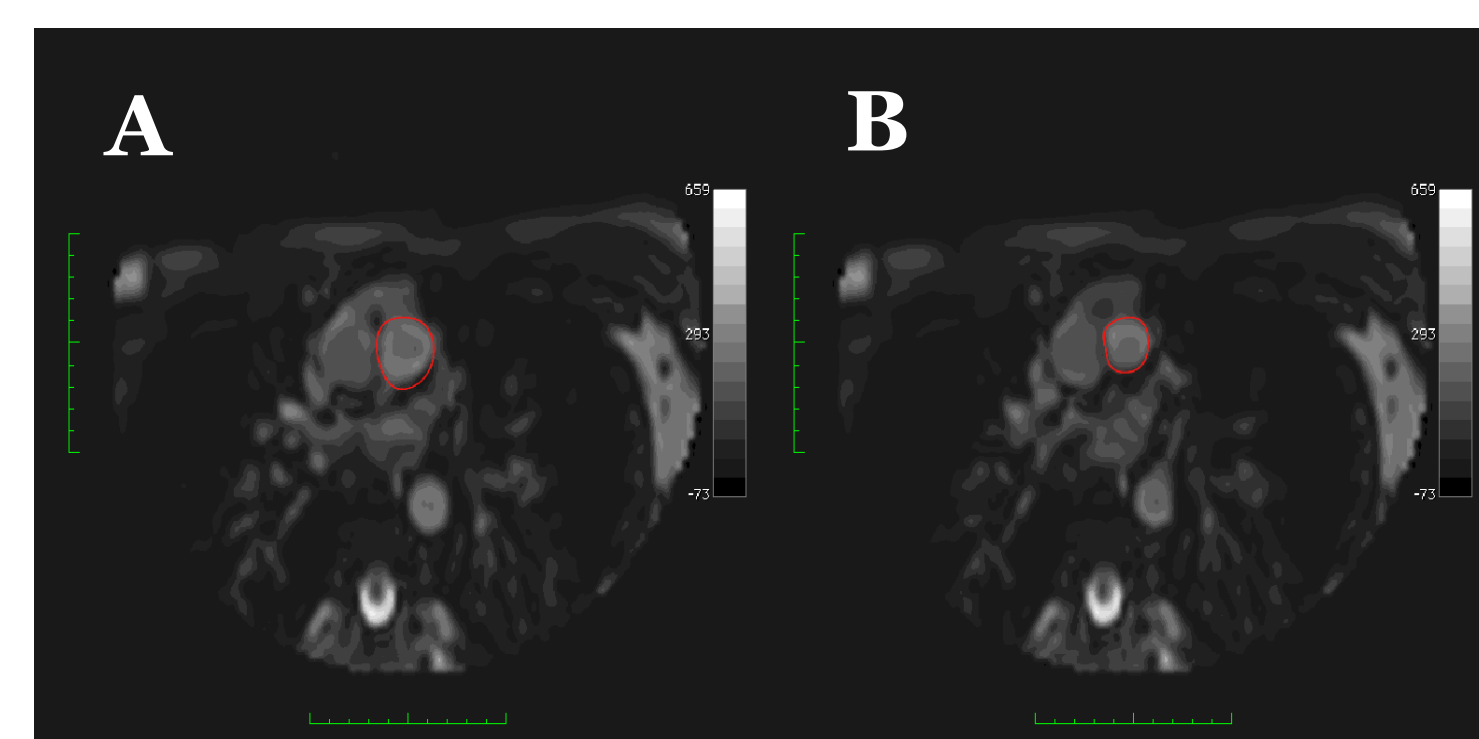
Real-time MRI images of systole (A) and diastole (B) of the subject's heart during exercise; red circles indicate the pulmonary artery
